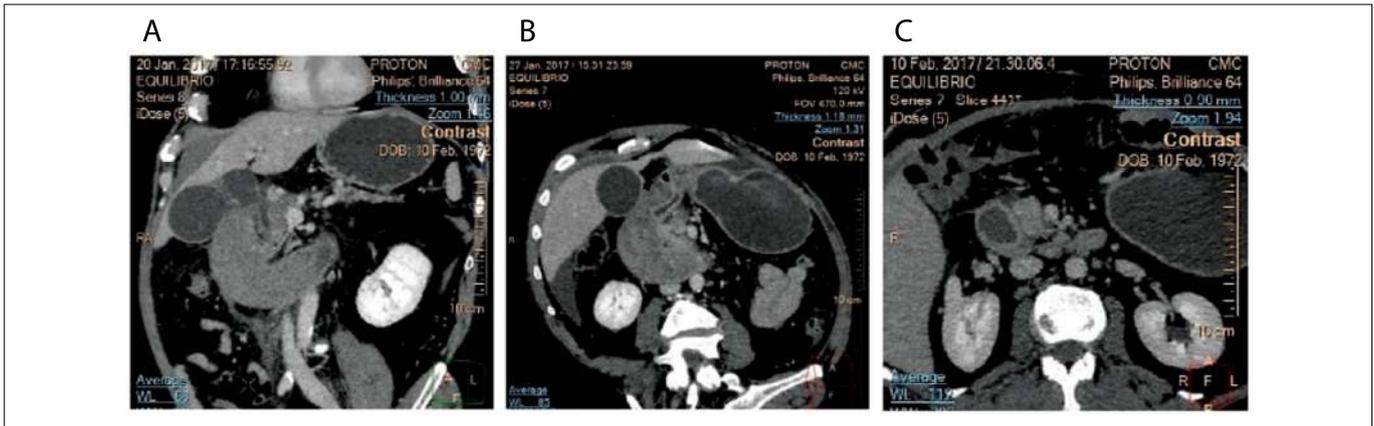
Computed tomography scans: A) at admission; B) post-embolization; C) post-surgical control.
